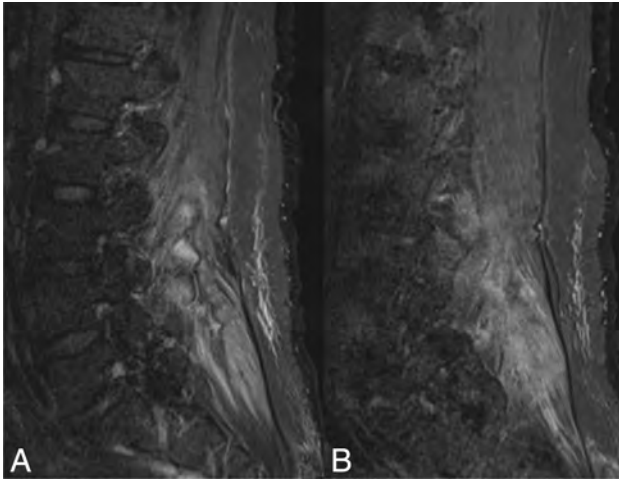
A 54-year-old woman with COVID-19. Sagittal fat-saturated T2-weighted imaging of the lumbar spine demonstrates nearly symmetric areas of increased T2 signal intensity within the posterior paraspinal muscles bilaterally. A, right parasagittal view of the T2 signal hyperintensity in the right paraspinal musculature. B, left parasagittal view of the T2 signal hyperintensity in the left paraspinal musculature.
